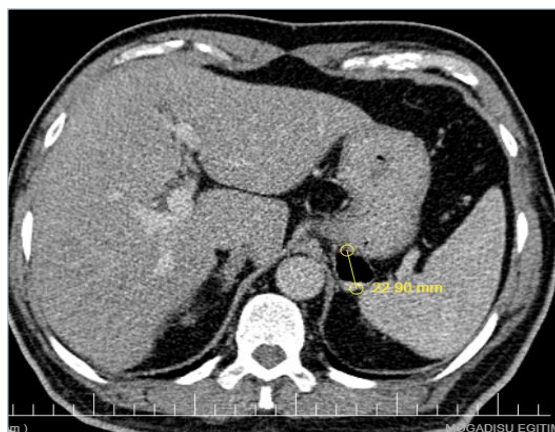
Computed tomography showed an exophytic diverticulum extending from the stomach fundus (yellow arrow).
